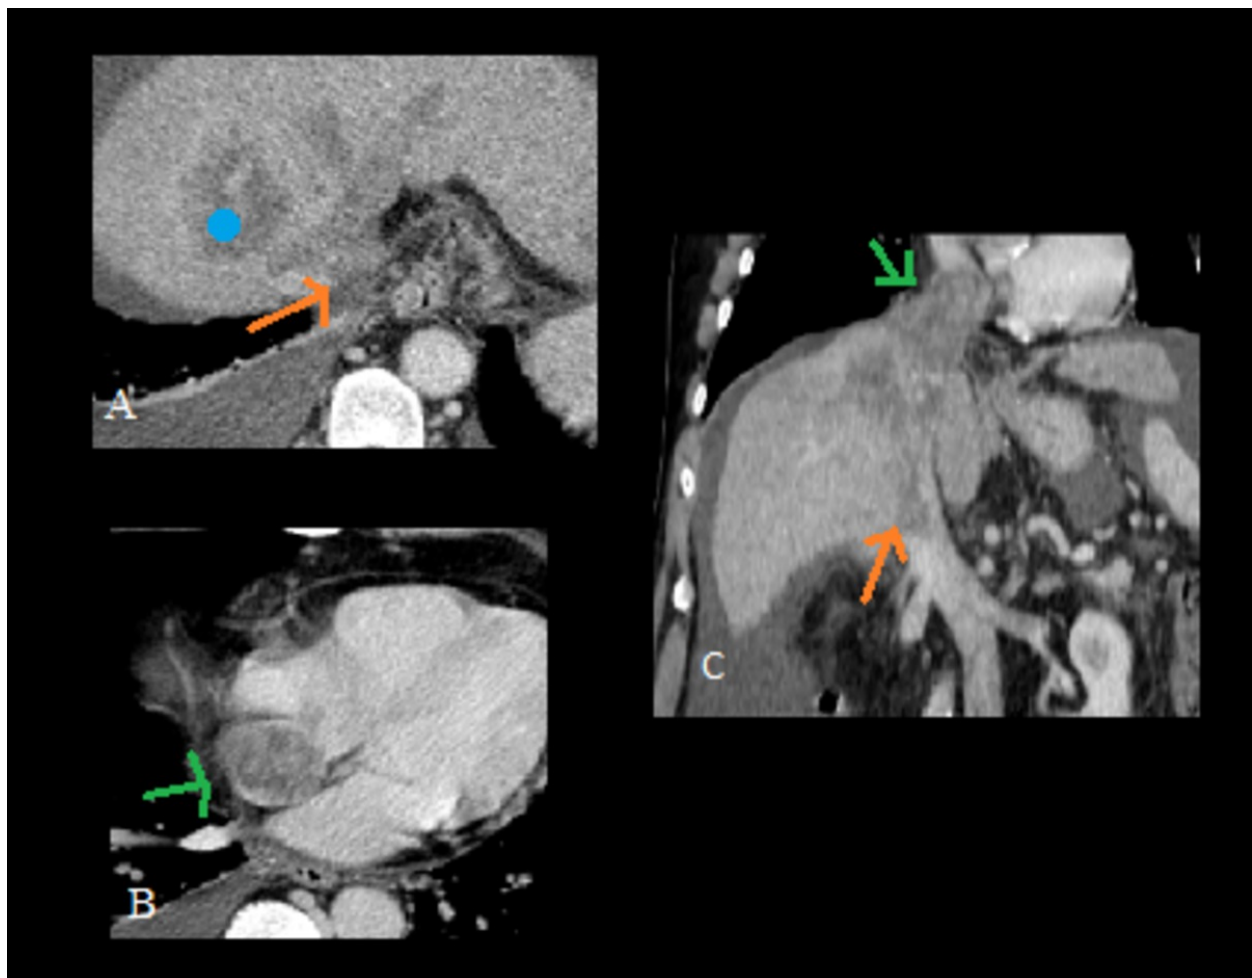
Malignant IVC thrombosis: Contrast-enhanced CT scans reveal a large HCC (blue dot) extending to the IVC (orange arrow) and right atrial appendage (green arrow).
